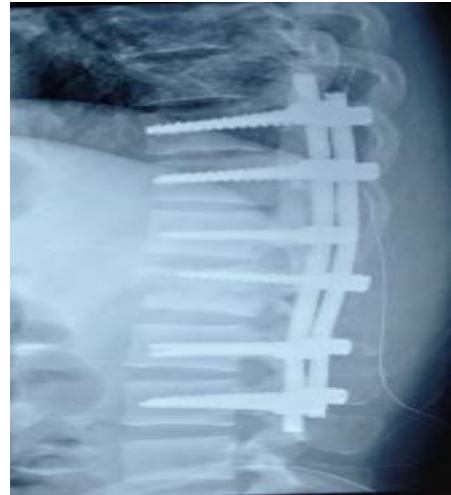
Immediate postoperative x-rays.
